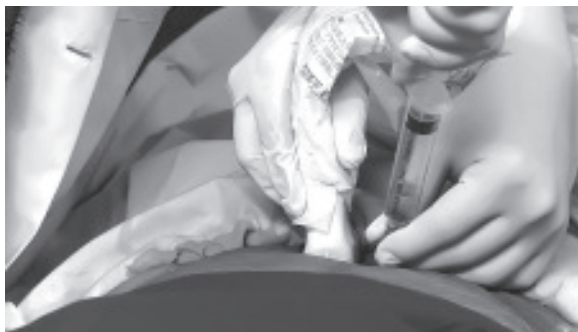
“two operators’ technique”, one for manipulating the ultrasound probe to create the image and other for needle maneuvers.
